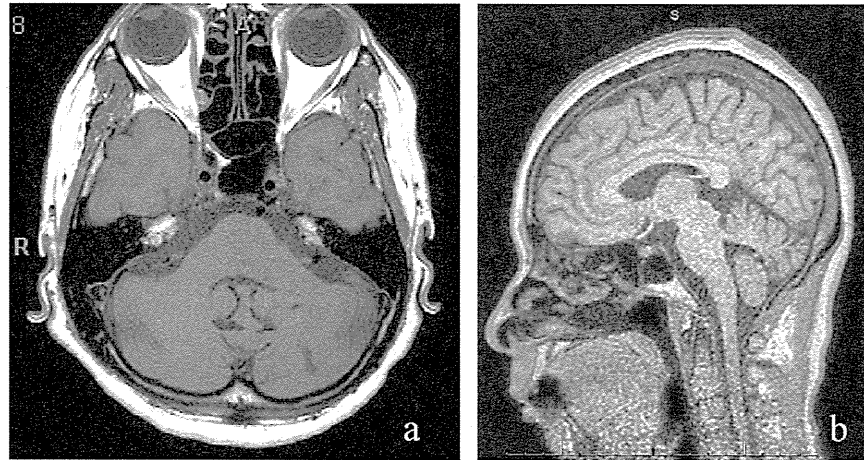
Axial and sagittal T1-weighted MRI findings (a and b). Both images show moderate diffuse atrophy of the pons and cerebellum.
